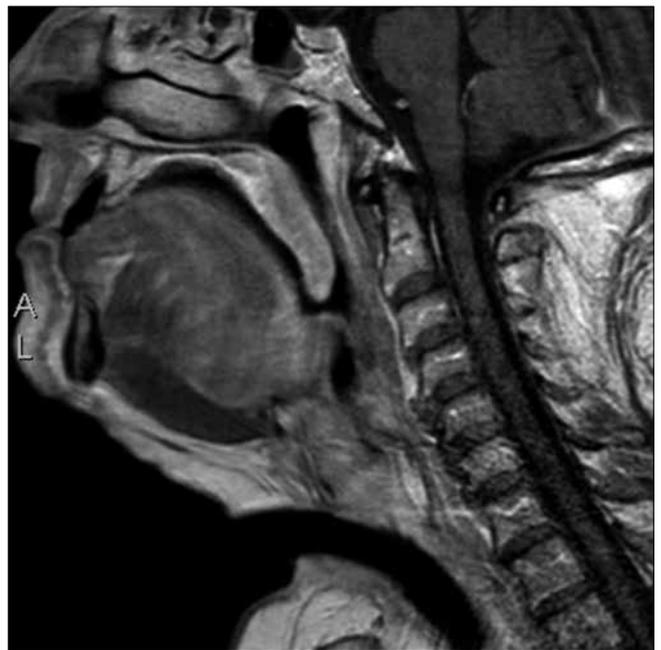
MRI examination highlighted a muscular verticalised BOT with a significant narrowing of the upper airway.
